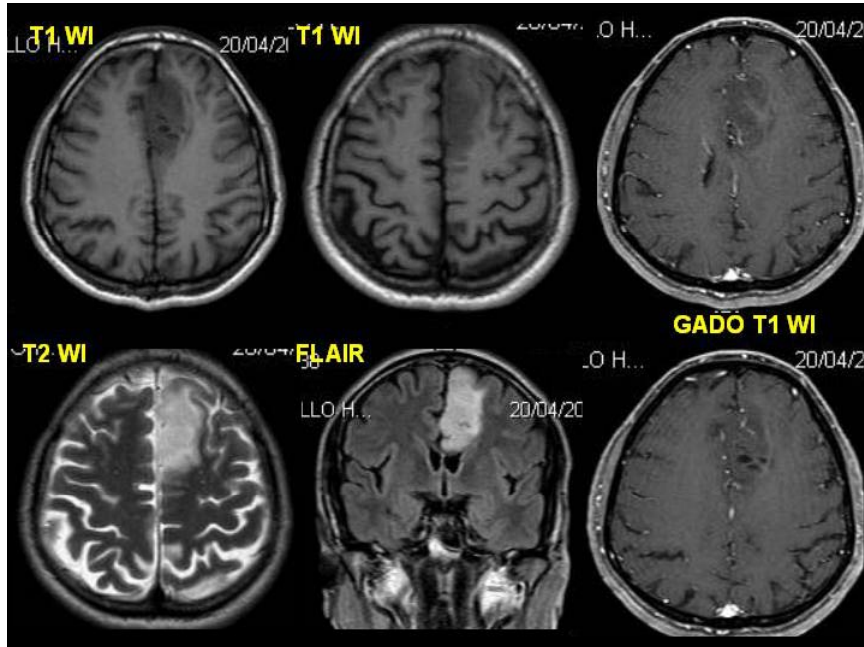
MRI shows, signal alteration on T2 WI in the left medial frontal cortex and non-enhancing on Post gadolinium contrast study – A nonspecific finding in the left frontal cortex – Focal cerebritis or neoplasm
